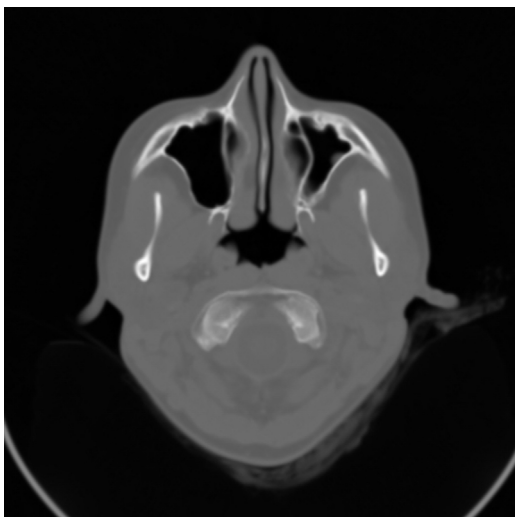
CT showing incomplete opacification of a hypoplastic left maxillary sinus.
